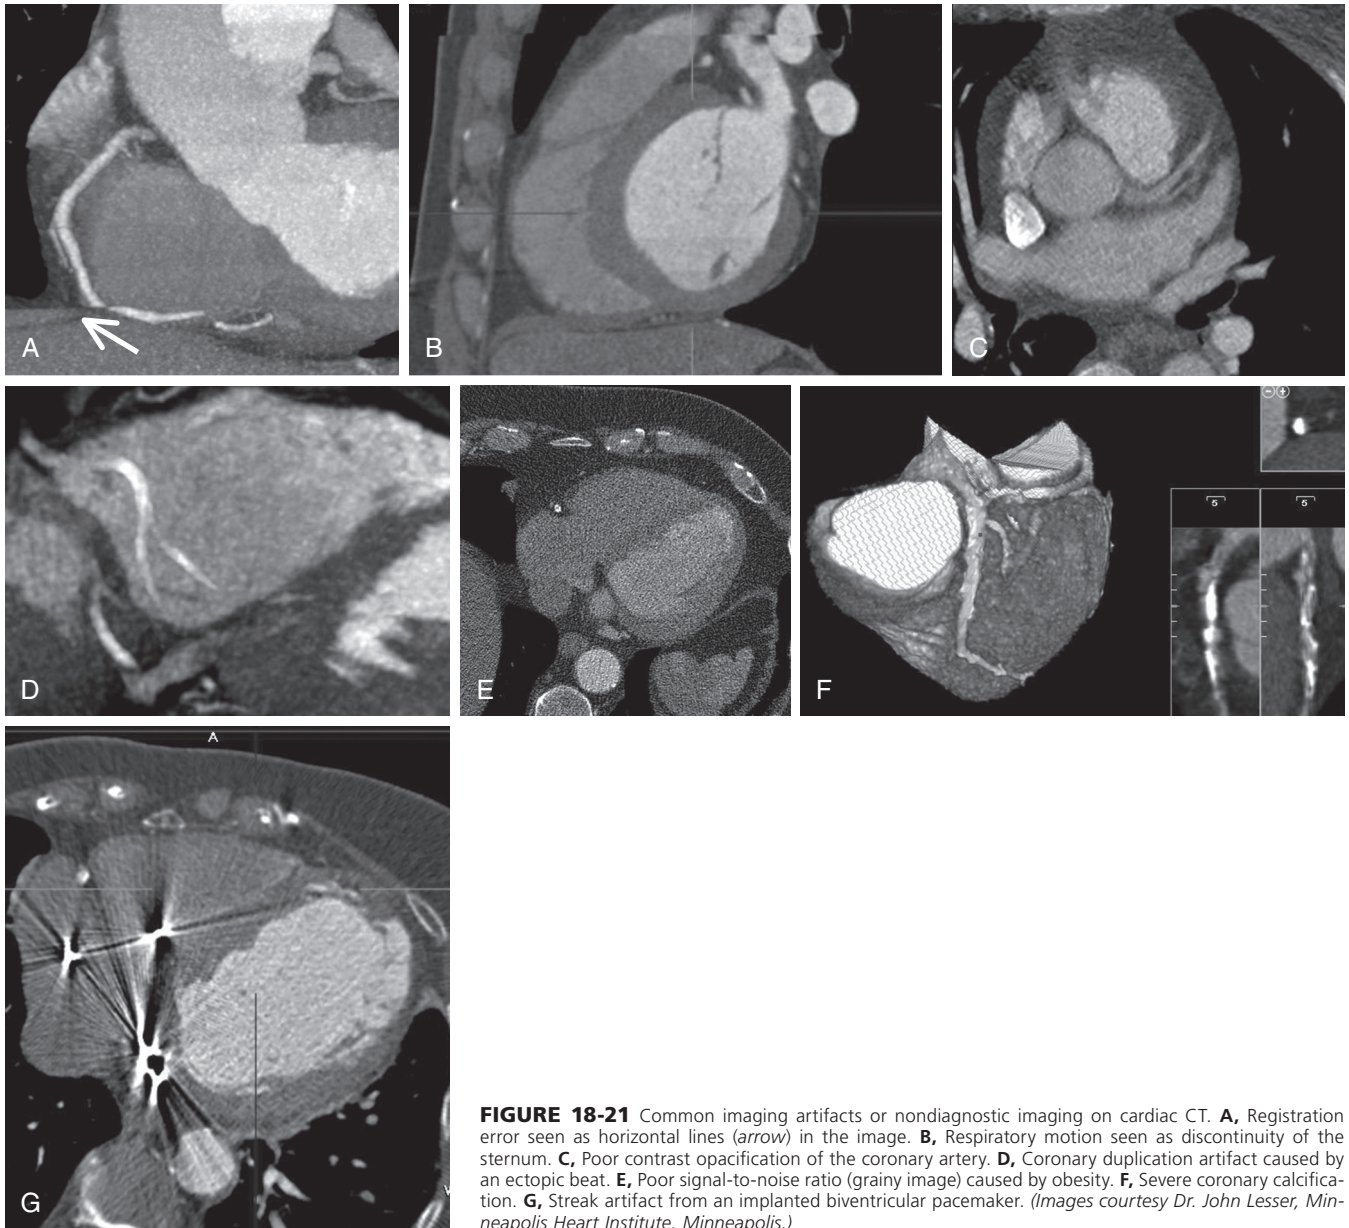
Common imaging artifacts or nondiagnostic imaging on cardiac CT. A, Registration error seen as horizontal lines (arrow) in the image. B, Respiratory motion seen as discontinuity of the sternum. C, Poor contrast opacification of the coronary artery. D, Coronary duplication artifact caused by an ectopic beat. E, Poor signal-to-noise ratio (grainy image) caused by obesity. F, Severe coronary calcification. G, Streak artifact from an implanted biventricular pacemaker. (Images courtesy Dr. John Lesser, Minneapolis Heart Institute, Minneapolis.)
